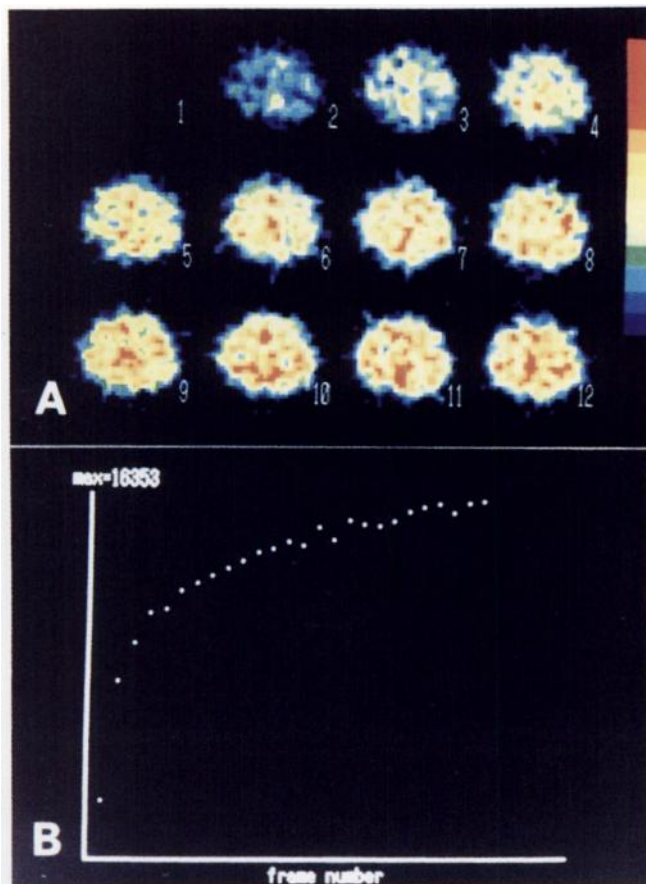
Twelve serial dynamic SPECT images (A) and the changes of the reconstructed counts on the ROI placed over a cerebral hemisphere (B) in the same subject as shown in Figure 1.
